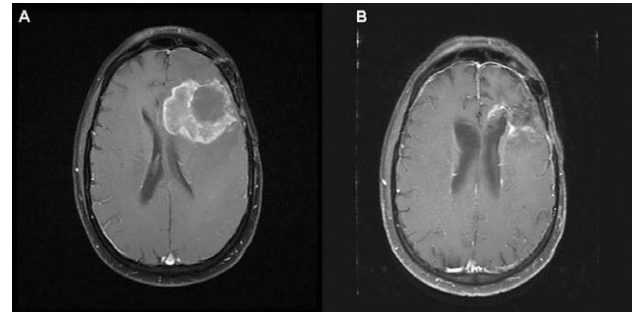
T1 postcontrast axial MRI images of the brain. (A) Two months after resection revealing radiation necrosis, there is additional progression of enhancement. (B) Interval decrease in the enhancement without intervention 15 months later.
